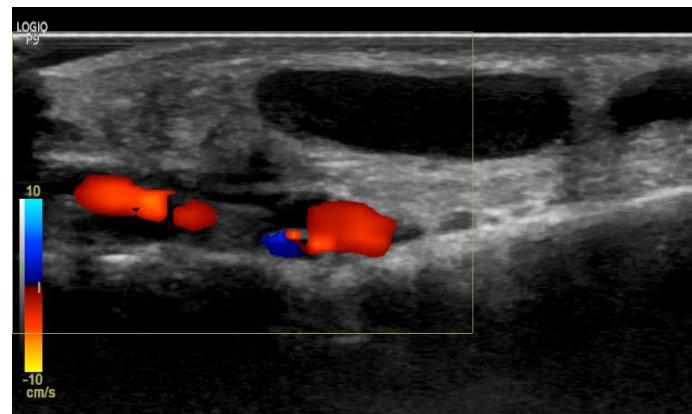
Dilated Primary Aneurysm of the Medial Marginal Vein of the Foot with color Doppler.
